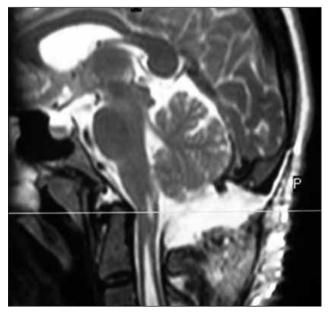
Post-decompression midsagittal T2-weighted MRI. The line is drawn through the region of interest at the foramen magnum level.
